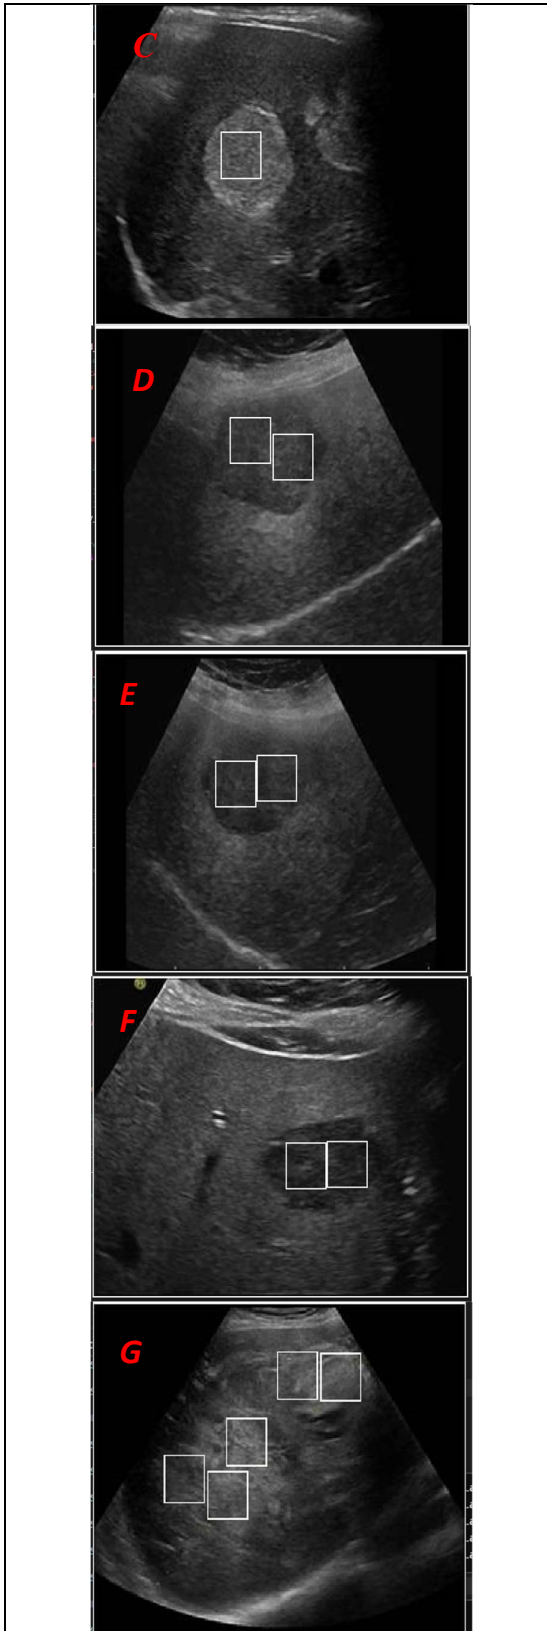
Sample images of large HCC from ultrasoundcases.info [2] (a), (b) and (c) contains Solitary Lesions.
